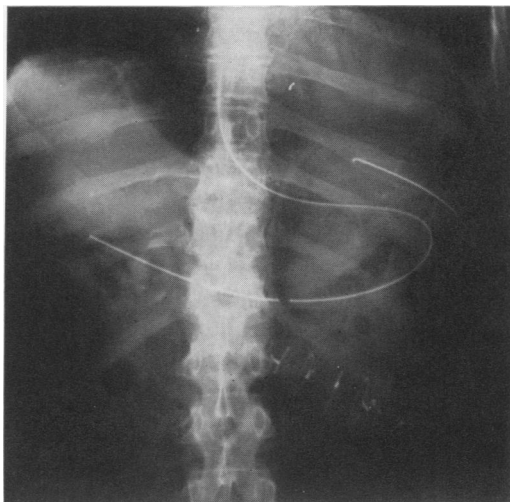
Case 1. X-ray of abdomen showing radiopaque nasogastric tube in stomach and catheter in left subphrenic space for the application of suction.
